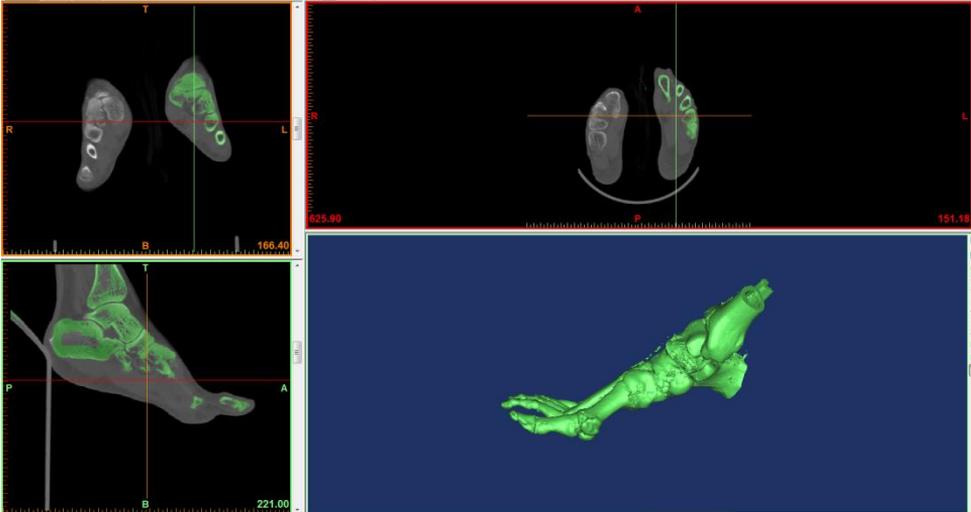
3D foot reconstruction from DICOM CT slices
